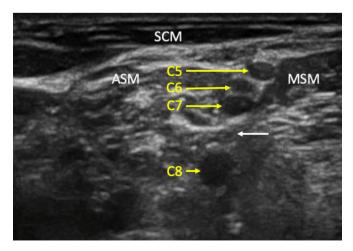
Ultrasound image of the interscalene gap. A muscle bridge (indicated by the white arrow) sperates the C7 from the C8 ventral rami. ASM, anterior scalene muscle; MSM, middle scalene muscle; SCM, sternocleidomastoid muscle.
